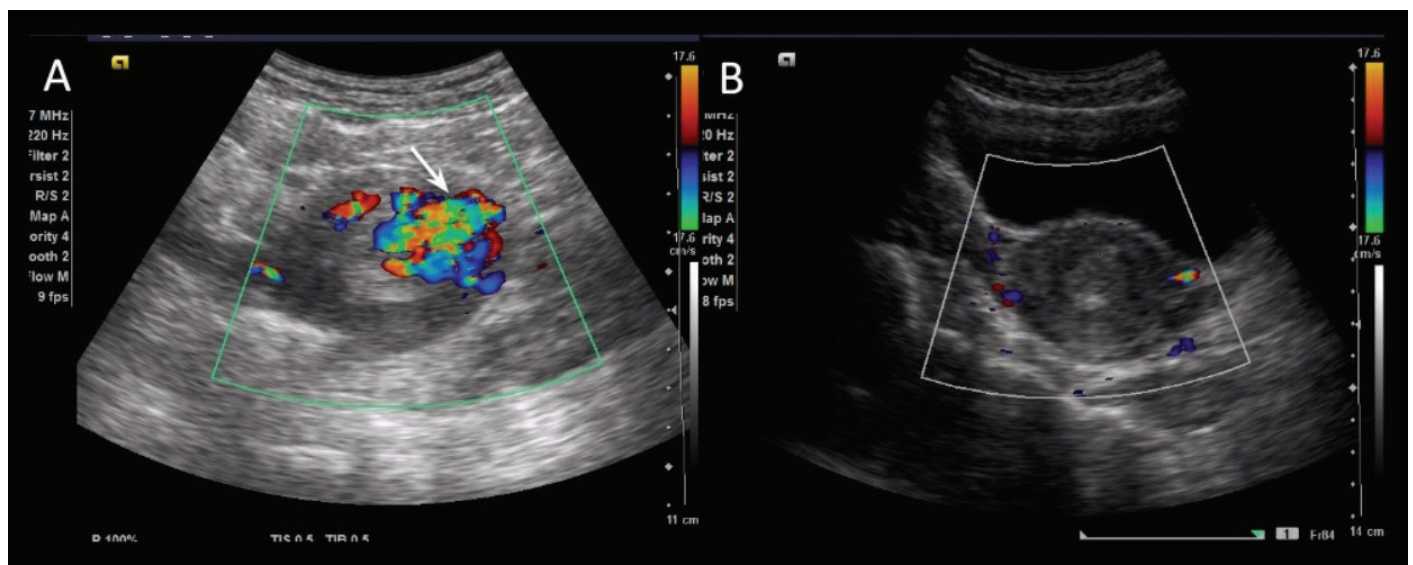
(A) Pre-embolization ultrasound Doppler image (A) showing bunch of vascular channels within the uterine wall (arrow) suggestive of uterine AVM. (B) Post embolization Doppler image (B) showing complete obliteration of nidus of AVM
